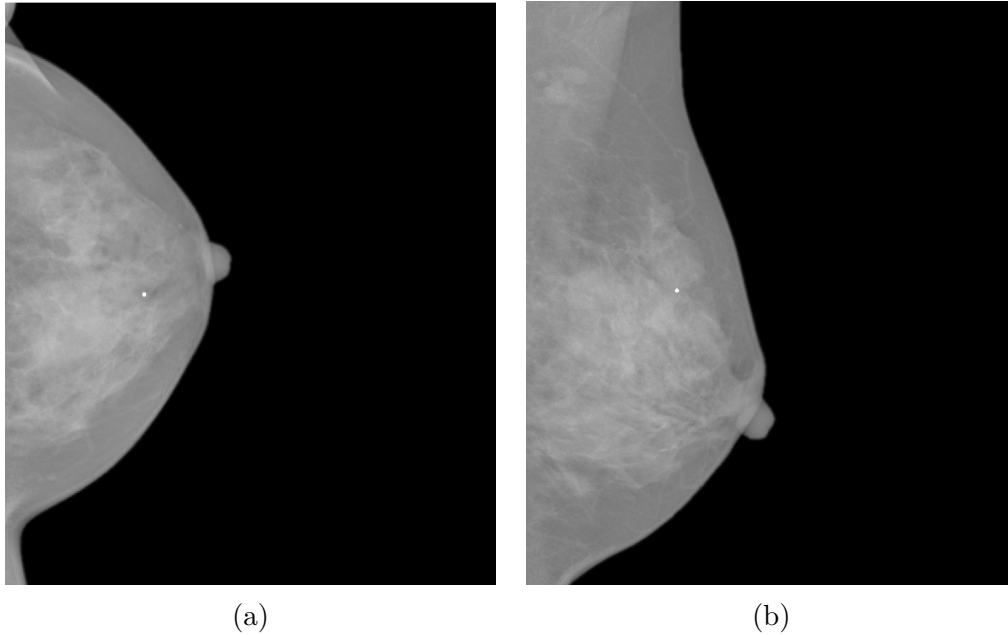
X-ray mammogram: (a) CC view; (b) MLO view
